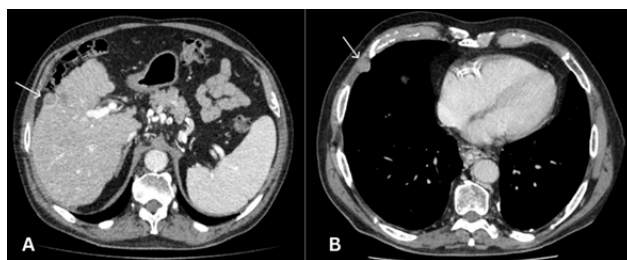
(A) CT after 9 months demonstrating a new recurrence site near the original ablation zone, with a nodule with portal venous washout (arrow). (B) Growth of the previously missed nodule (arrow).
